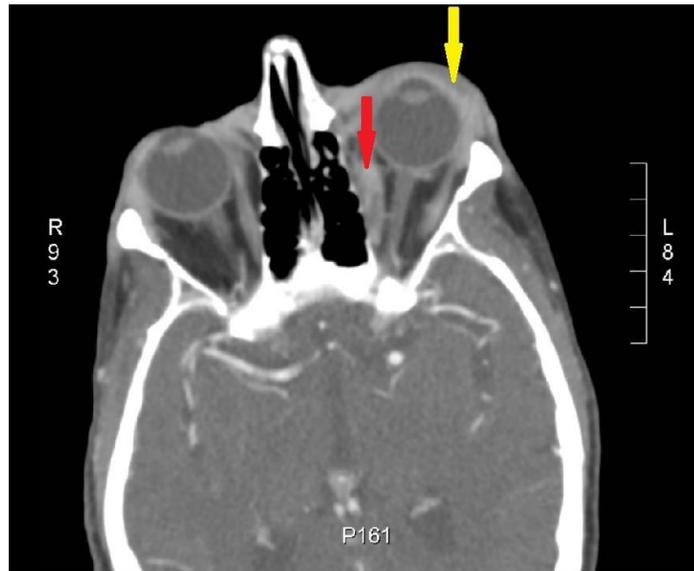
CT scan showing left sided medial rectus infiltration (red arrow), along with periorbital softtissue thickening (yellow arrow). This scan also shows mild proptosis of the left eye, although overaccentuated due to head rotation and lid tissue thickening.
